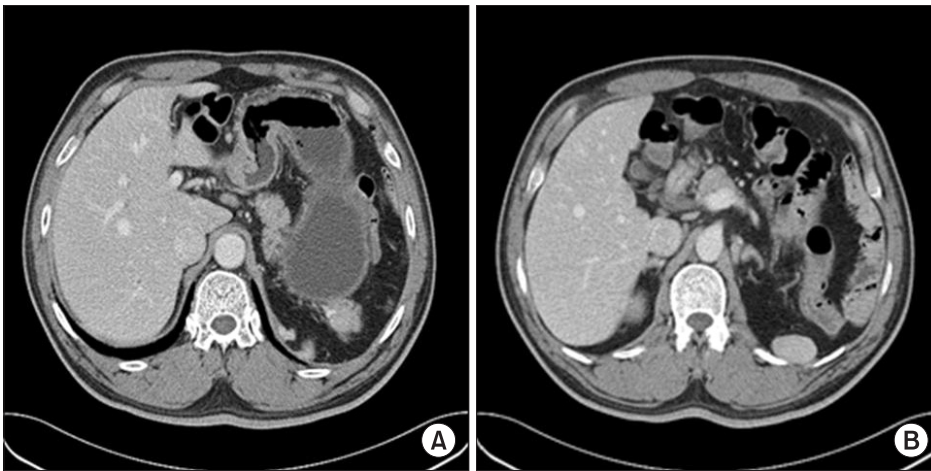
The axial intravenous contrast enhanced CT scan (the portal venous phase image). (A) Note the wall thickening of the anterior wall of the antrum in the stomach and the lymph node enlargement in the perigastric area. (B) Note the 3.5×1.5 cm sized splenic tissue in the left subdiaphragmatic area with no supplying splenic vessel. CT = computed tomography.
